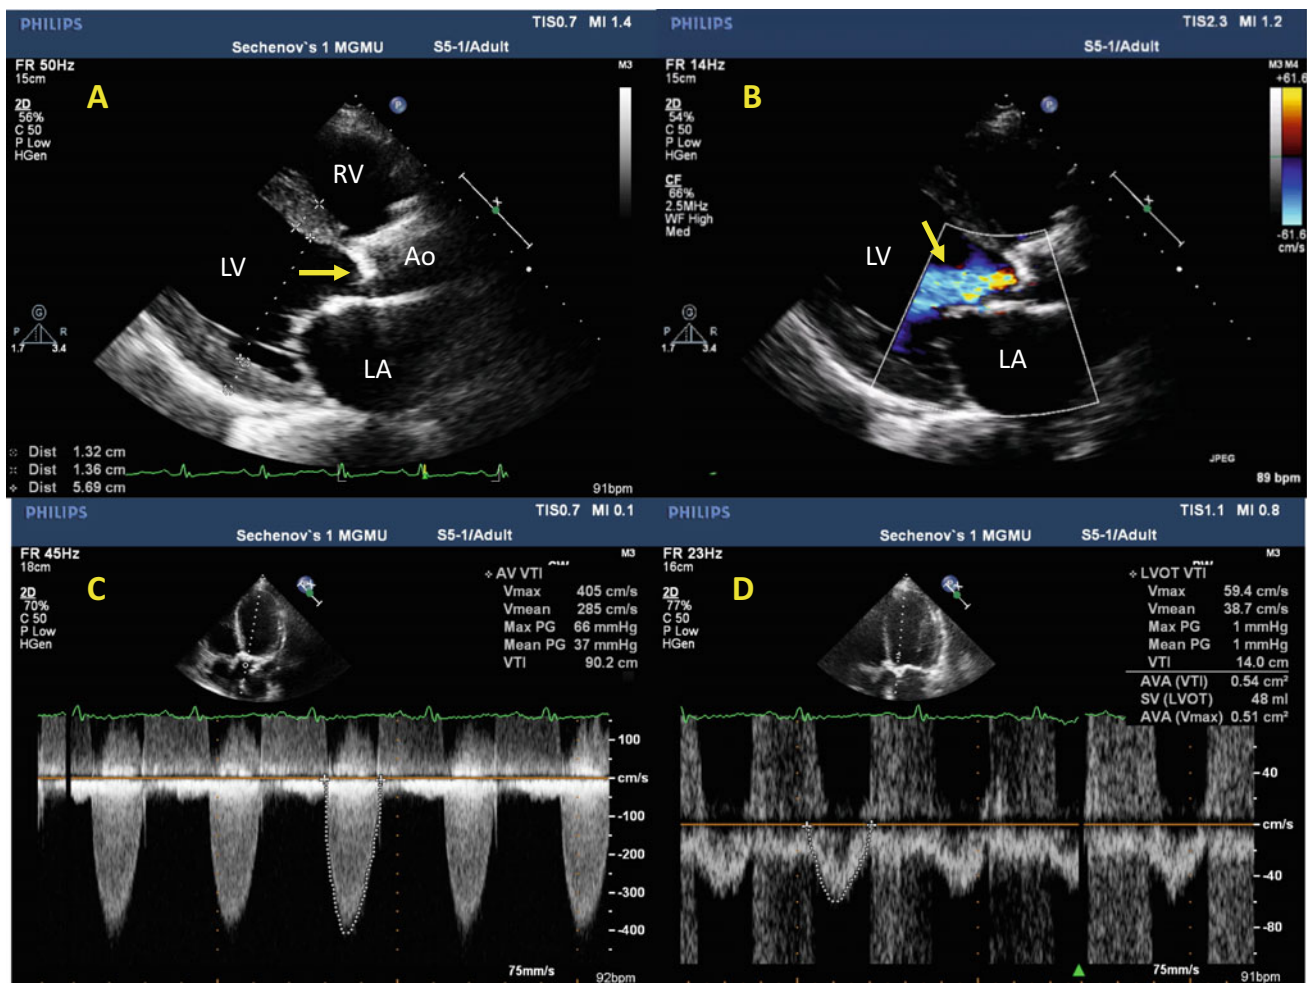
Echocardiogram in 2016 before transcatheter aortic valve replacement (TAVR). a Thickening of aortic valve cusps (arrow) and annulus. Moderate LV hypertrophy. Parasternal long axis view. RV = right ventricle, LV = left ventricle, Ao = Aorta, LA = left atrium. b Color Doppler of aortic regurgitation. The arrow points at the moderate regurgitant jet. Parasternal long axis view. c Doppler echocardiography defining the severity of aortic stenosis. Maximal AV peak jet velocity (V_{\max}) of 405 cm/s indicates severe stenosis. Mean
